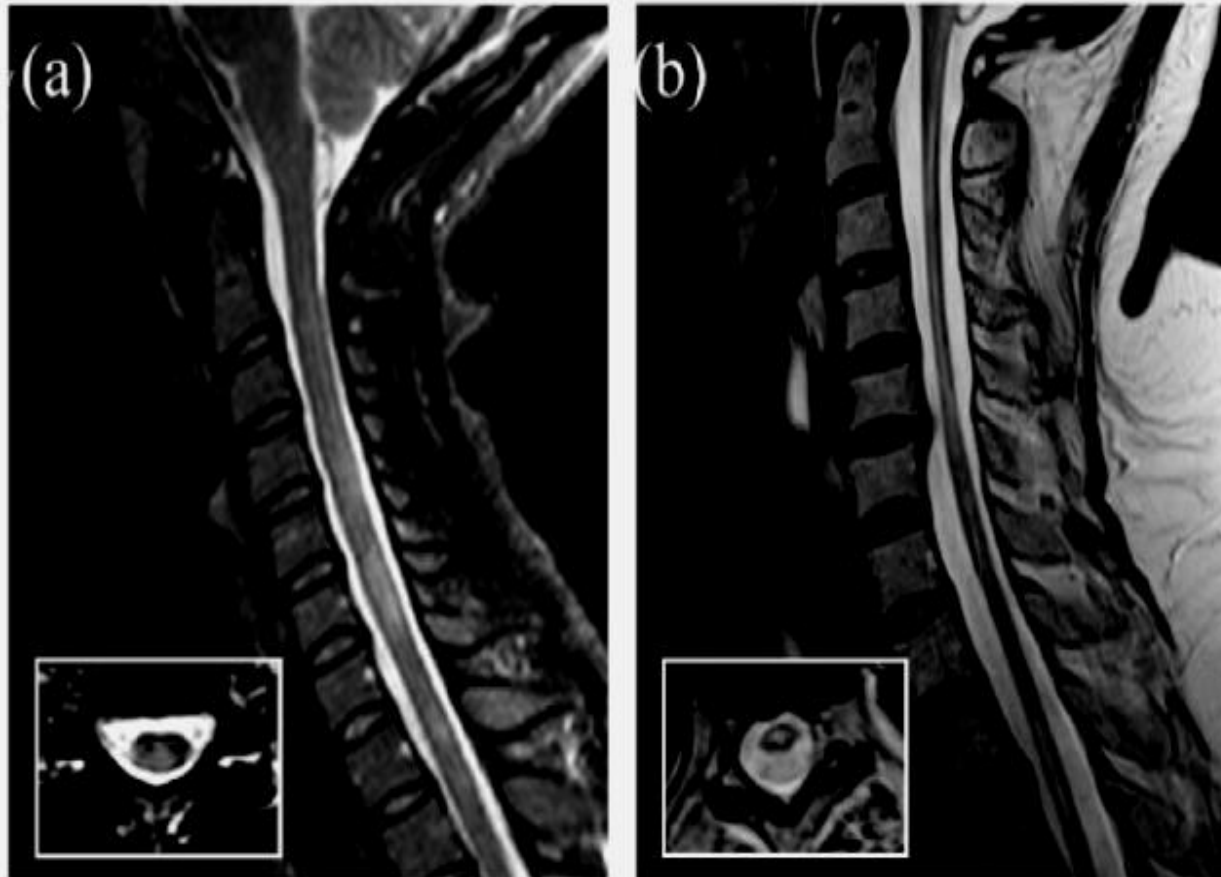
In MS (A), MRI shows areas of T2 hyperintensity which extend for a single vertebral level, involve both grey and white matter in the lateral-posterior part of the cord and have a cylindrical shape on the sagittal and a wedge shape on the axial view. NMO (B), there is a longitudinally extensive transverse myelitis from C1 to C5 and a lesion at T2–T3, with preferential involvement of the central spine.
